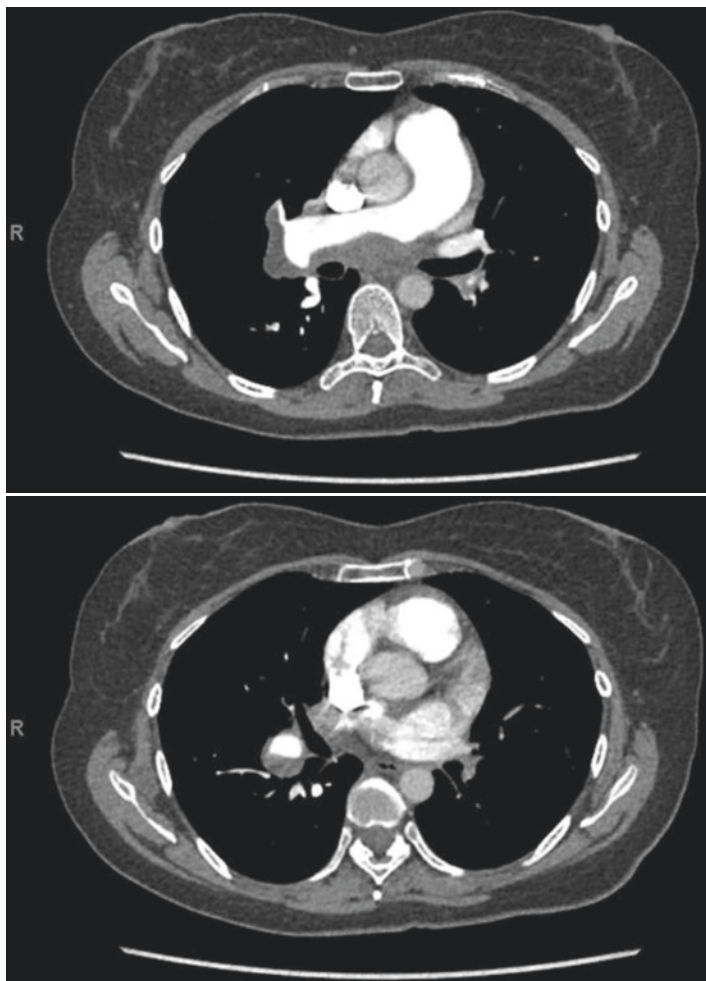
Above: computed tomography angiography (mediastinal window) showing proximal thrombus in the right pulmonary artery. Below: proximal thrombus in the lumen of the right interlobar artery
